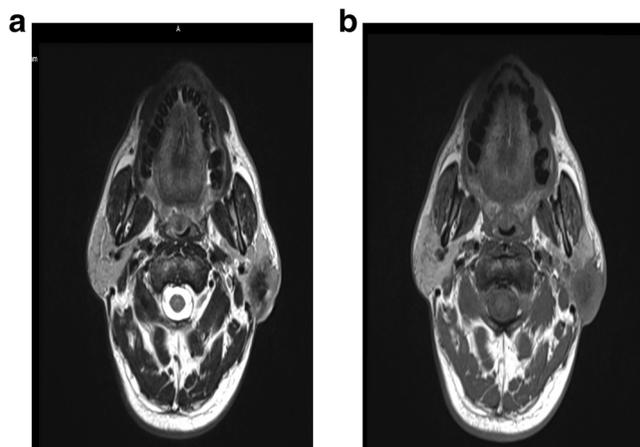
a T2-weighted magnetic resonance imaging showing a hypointense lesion in superficial lobe of the parotid gland. b T1-weighted magnetic resonance imaging showing a hypointense lesion in superficial lobe of the parotid gland
